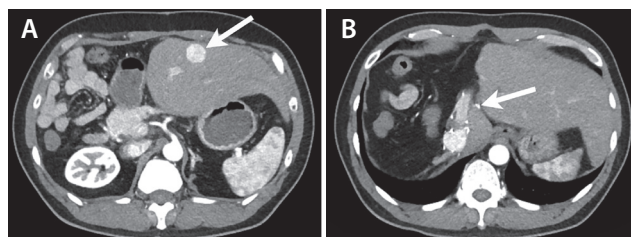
Arterial-phase CT image of the remnant liver 1 year after resection shows a new 2.1-cm lesion in segment 3 (arrow). Washout and pseudocapsule confirmed recurrent hepatocellular carcinoma (A). A second small nodule of hypervascularity is seen in the fissure of the ligamentum venosum adjacent to the left portal vein (arrow) but is too small to characterize further (B).
